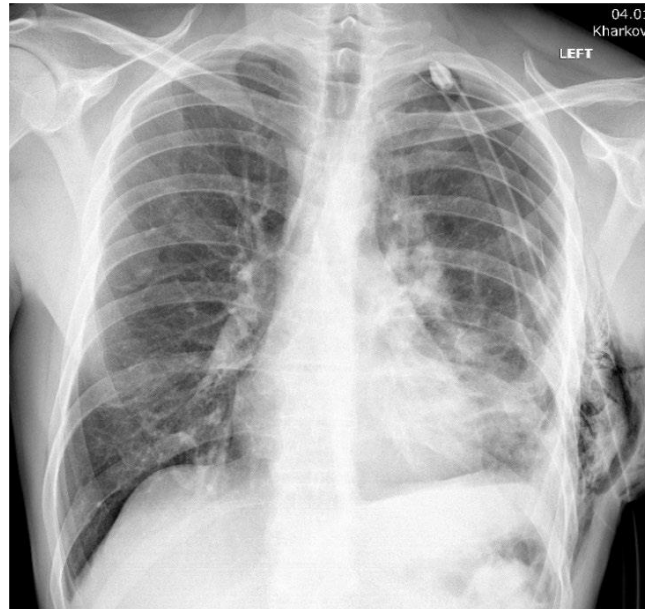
X-ray examination: a bruise of the left lung of the I degree, a pneumothorax of the I degree, local emphysema of soft tissues in the axillary region is determined.
